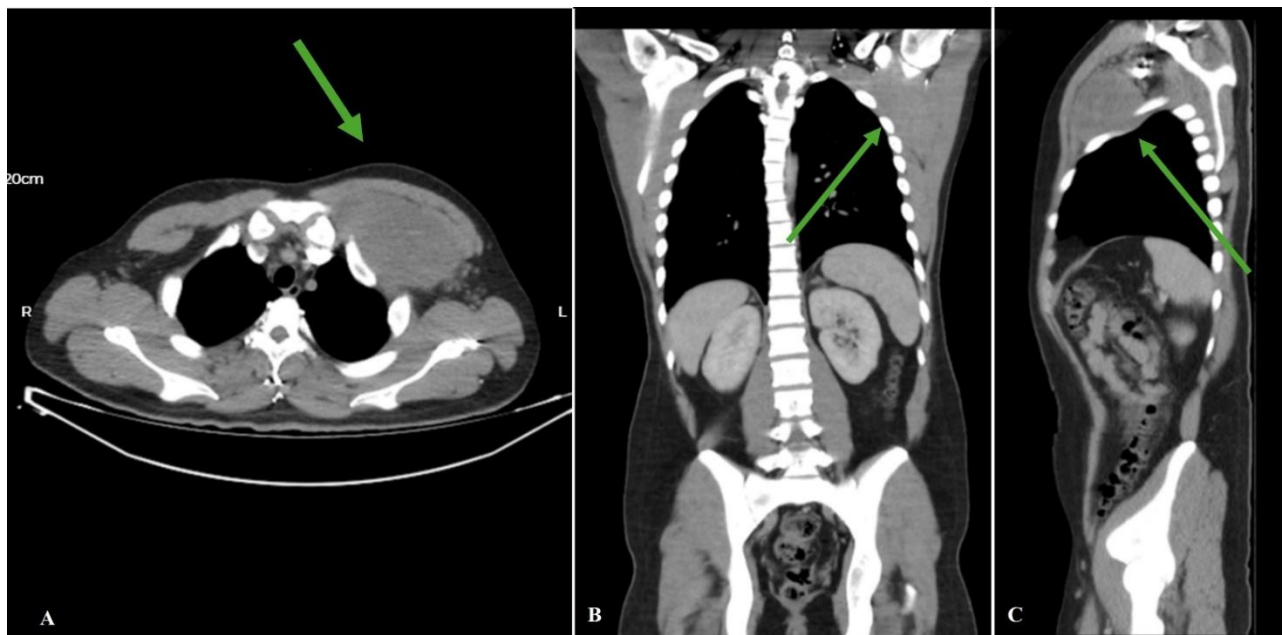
Initial contrast-enhanced thoracoabdominal computed tomography (CT). A: Transverse view. B: Coronal view. C: Sagittal view. Revealed an 8 x 12 cm mass with heterogeneous content, highlighted with a green arrow.
